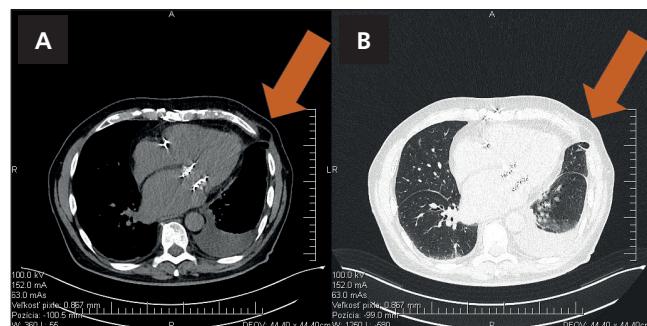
Computed tomography (transverse slices) of the patient with lung hernia before surgery (the orange arrows show the sac of the hernia).
